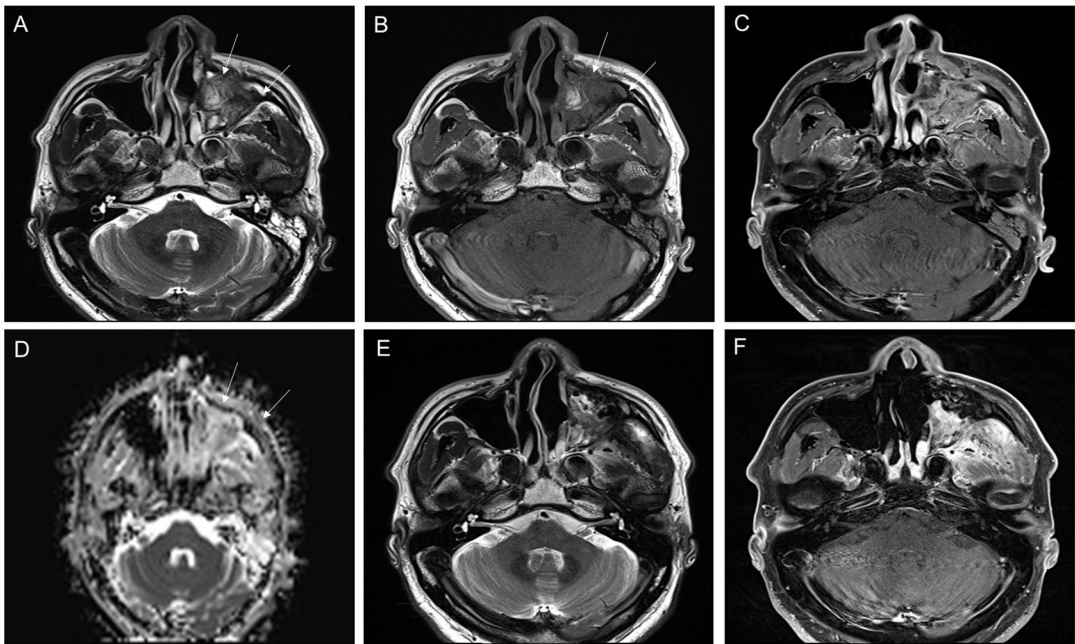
(A-D) Case of post-treatment change. 58-year-old man with left maxillary sinus cancer received operation. On surveillance MRI after 6 months, enhancing lesion was detected in the left maxillary sinus. (A-B) T2WI & T1WI shows heterogeneous signal intensity soft tissue in posterior portion of flap margin. (C) CET1WI shows mild enhancement of lesion. (D) ADC map shows no definite diffusion restriction of the lesion. Although two radiologists made different diagnosis on morphologic analysis, they made consensus to tumor recurrence after analysis of ADC map. The enhancing lesion remained stable on follow-up MRI after 3 years (E-F). So this case was regarded as post-treatment change.
